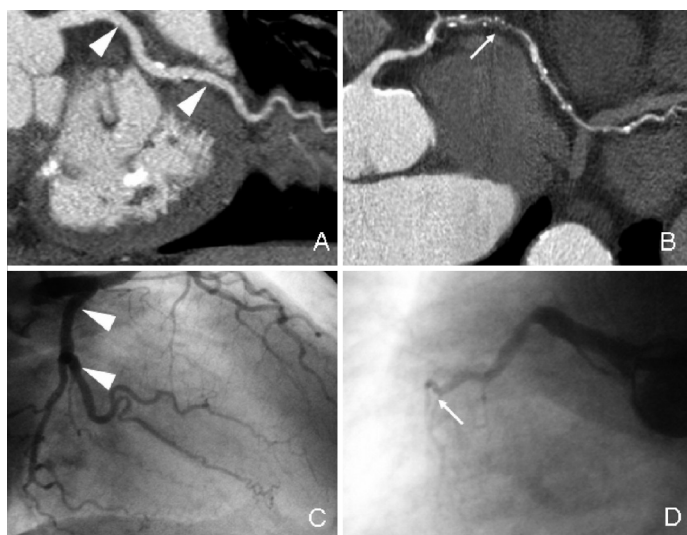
An example of a woman with obstructive coronary artery disease demonstrated with 64-slice multi-slice computed tomography (MSCT) coronary angiography. (A) Multiplanar reconstruction (MPR) of the left circumflex coronary artery (arrowheads) with minimal irregularities of the artery wall. (B) MPR of the right coronary artery showing occlusion in the middle part of the vessel (arrow). The distal part of the artery is filled through collaterals. (C, D) The findings were confirmed by conventional coronary angiography (arrowheads and arrow).
